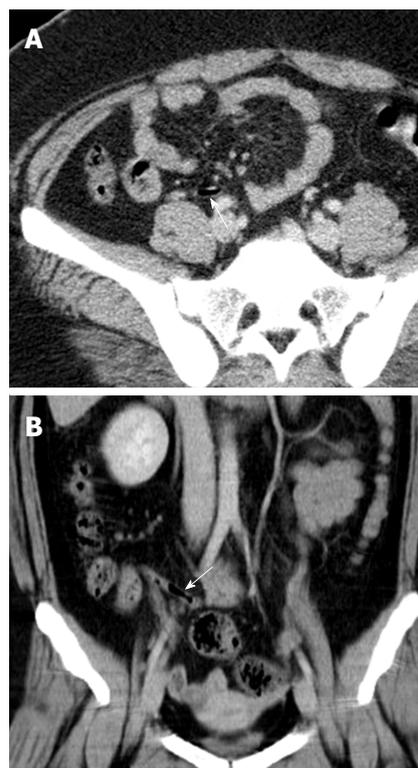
Appendiceal intraluminal air. A: Cross-sectional (arrow); B: Coronal abdominal computed tomography scans showing appendiceal intraluminal air suggestive of normal appendix (arrow).
